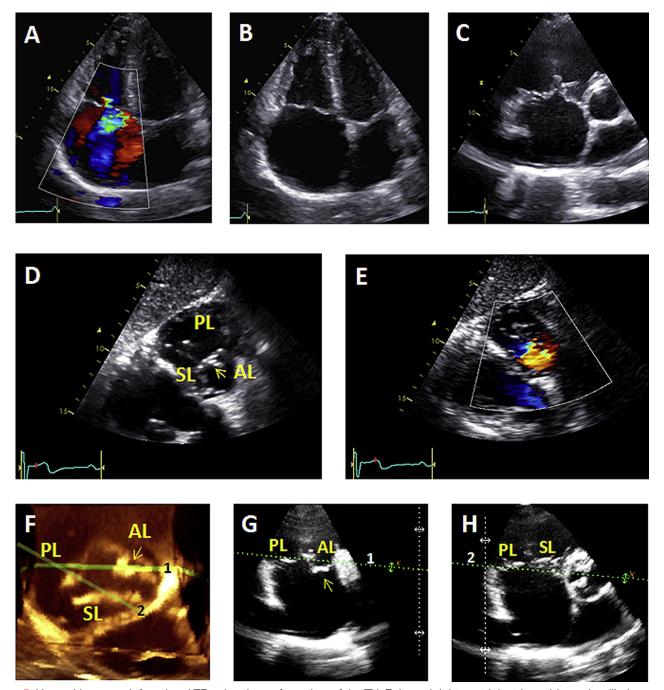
Unmasking pseudofunctional TR using the en face view of the TV. Enlarged right ventricle, tricuspid annular dilation, and a normal appearance of the tricuspid leaflets in the standard parasternal and apical views were suggestive of functional TR in this patient with moderate pulmonary hypertension (A–C). The en face view of the TV by the subcostal approach allowed an immediate identification of the anterior leaflet prolapse (D, arrow) (Video 4; available at www.onlinejase.com) and the origin of the consequent TR jet (E) (Video 5; available at www.onlinejase.com). The en face view obtained by 3D echocardiography confirms the anterior leaflet prolapse (F, arrow), with green laser lines demonstrating the difference in scan-plane orientation between two PSAX views (G,H) (Videos 6 and 7; available at www.onlinejase.com). Reconstructed views show that, depending on transducer orientation, the prolapse may (G, arrow) or may not be clearly visible on the leaflet adjacent to the aortic valve when a PSAX view is obtained. AL, Anterior TV leaflet; PL, posterior TV leaflet; SL, septal TV leaflet.
